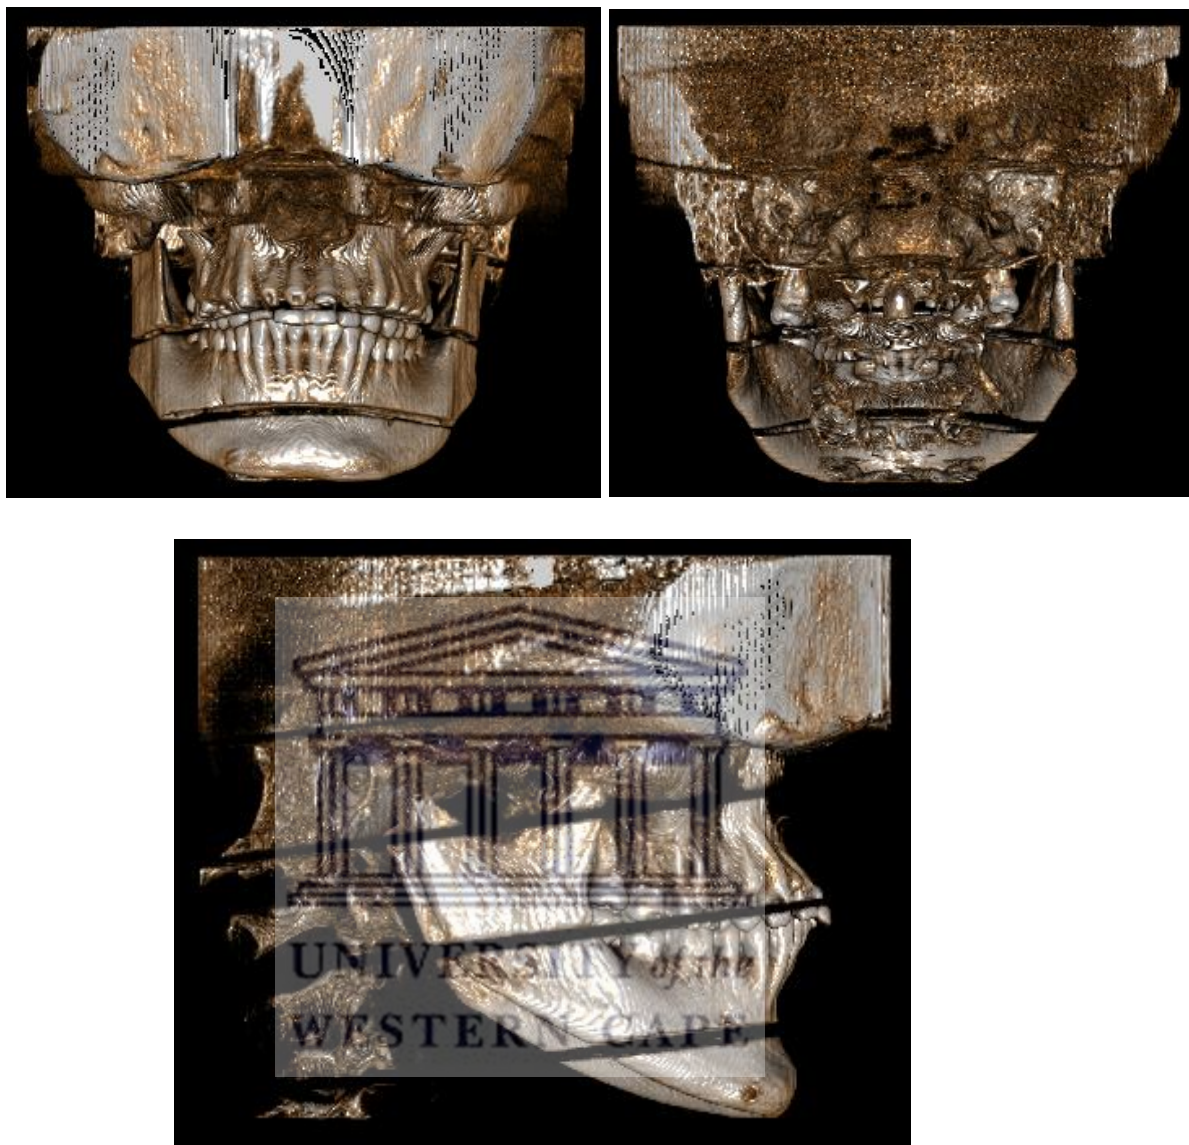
Anteroposterior (top) and lateral cephalometric (bottom) radiographic views of the CBCT volume with the attached modified shield (NewTom® 5GXL, FOV 15 × 12 cm, regular scan, and standard dose).
